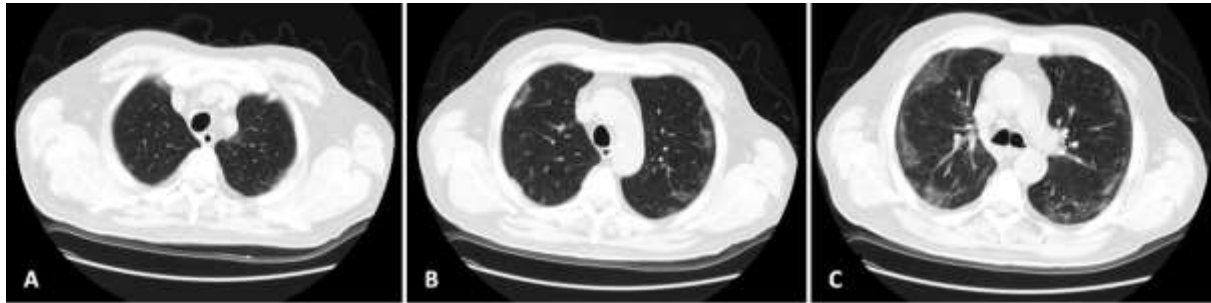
Axial CT images (A, B and C) showing the presence of air (arrows) in the mediastinal region.
